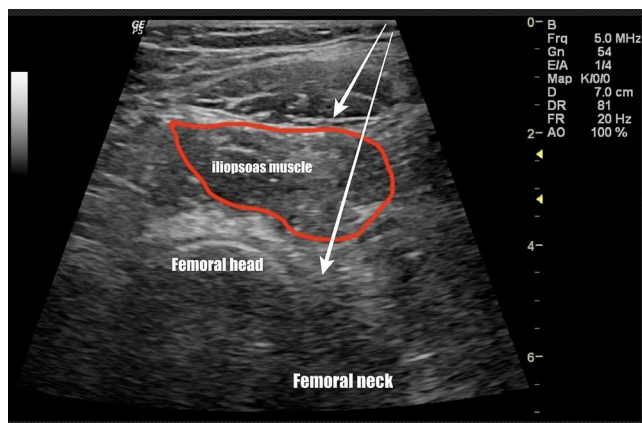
Ultrasound-guided hip injection technique arrows showing the trajectory for iliopsoas muscle needling and intra-articular injection.
